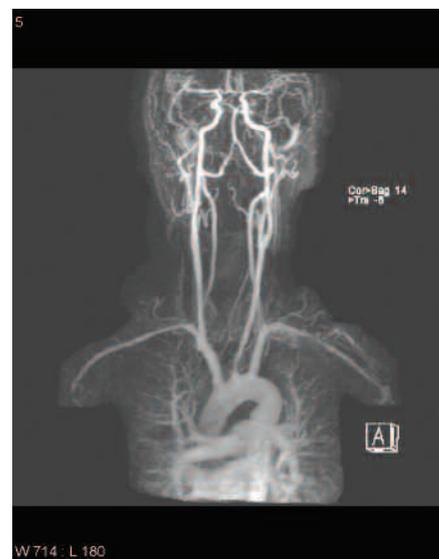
Magnetic resonance image of the thorax and neck showed concentric arterial wall thickening of the thoracic aortic arch (7 mm in maximum dimension), a proximal descending thoracic aorta, and supra-aortic arteries. Mild calibre reduction was evident in the proximal right subclavian and right vertebral arteries, and the left common carotid artery was stenosed approximately 35–40%.
